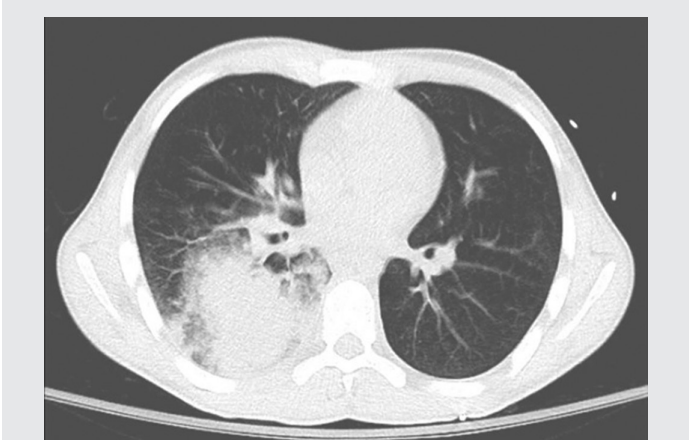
Computed tomography scan of the chest (axial plane) reveals a RLL infiltrate.
